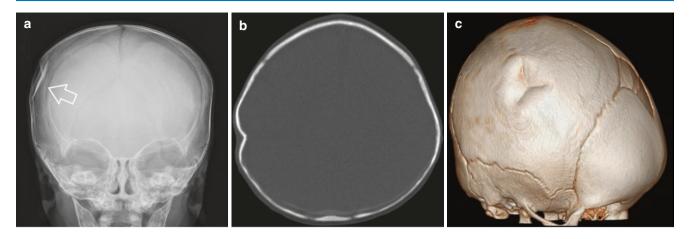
Infant who fell from a couch. (a) AP skull radiograph shows a ping-pong or celluloid fracture of the right parietal bone (arrow). (b) CT confirms the location of the fracture. (c) 3D reconstruction
